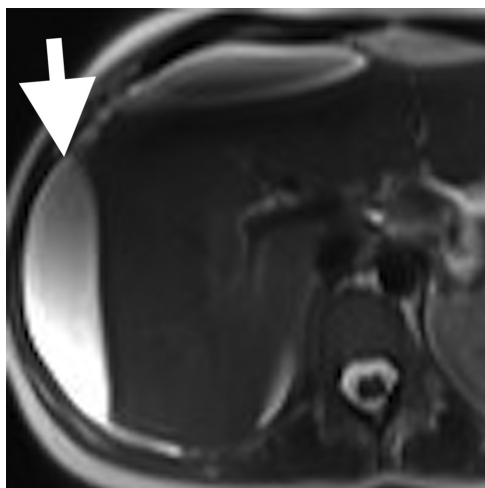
Axial T2-weighted image at the level of the liver demonstrating perihepatic fluid (arrow). No intrahepatic ductal dilation.
